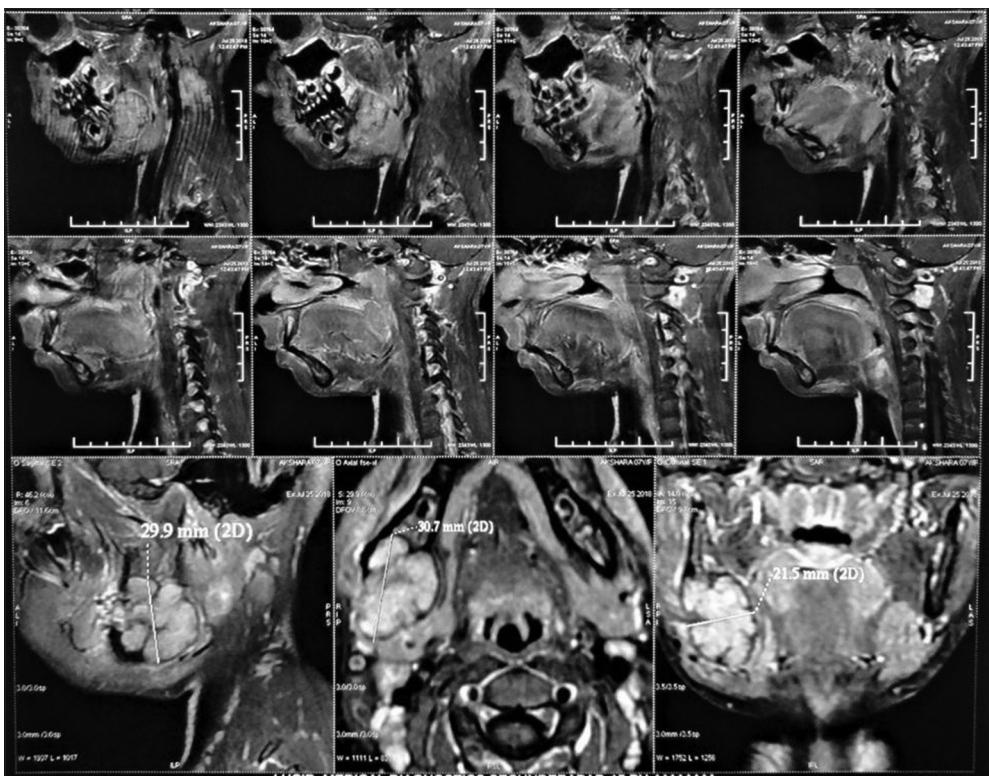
Magnetic resonance imaging of the lesion (sagittal and axial sections) revealing multiple enlarged submandibular and cervical lymph nodes, especially in the posterior triangle
